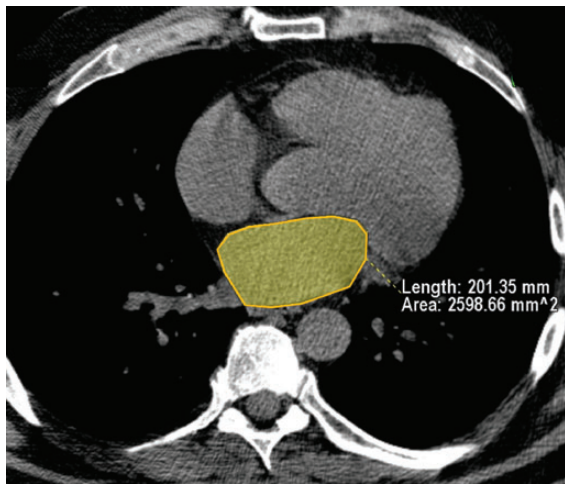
LA size measurement from an axial image from non-contrast-enhanced cardiac CT. The LA area was manually traced at the level of the left ventricular outflow tract and the height of the mitral valve leaflets, excluding the pulmonary veins.
